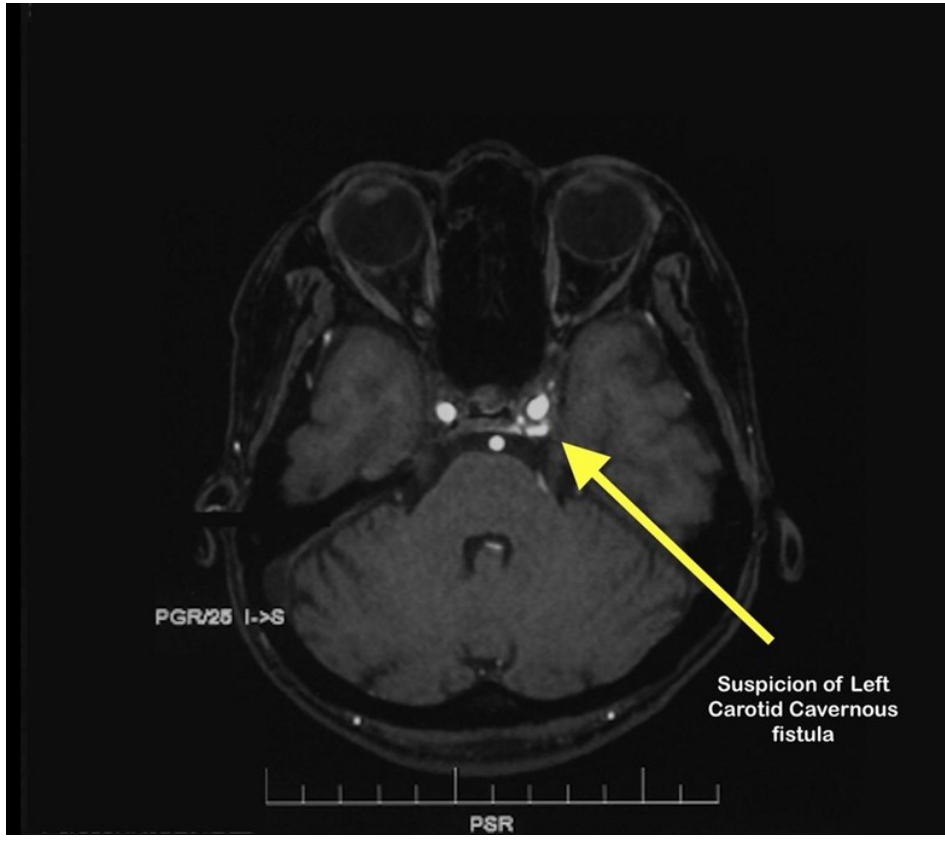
MRI brain showing axial cut at the level of cavernous sinus
